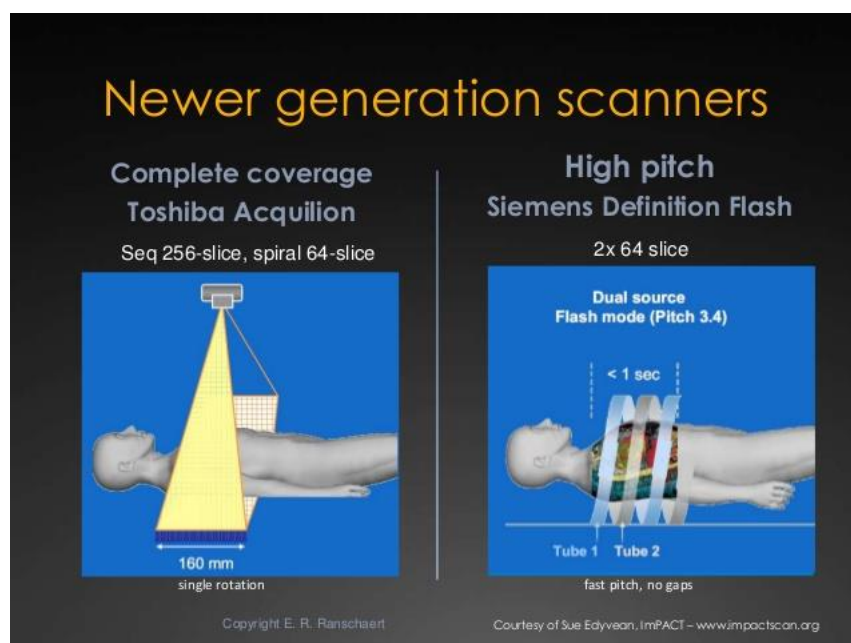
Images of the new generations scanner in cardiac computed tomography devices.
